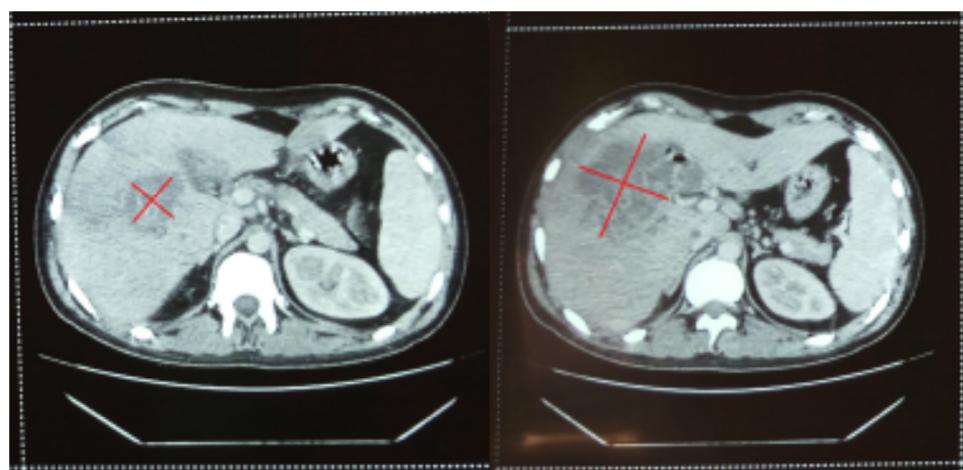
An abdominal contrast-enhanced computed tomography (CT) revealed an abscess in the right lobe of the liver with multiloculated hypodense collection.
